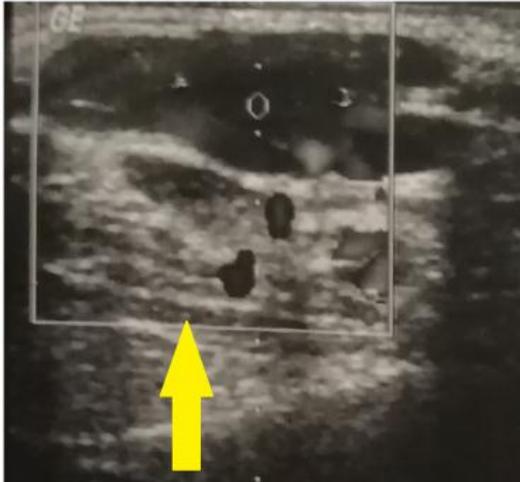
Hypoechoic mass at ultrasonography.
